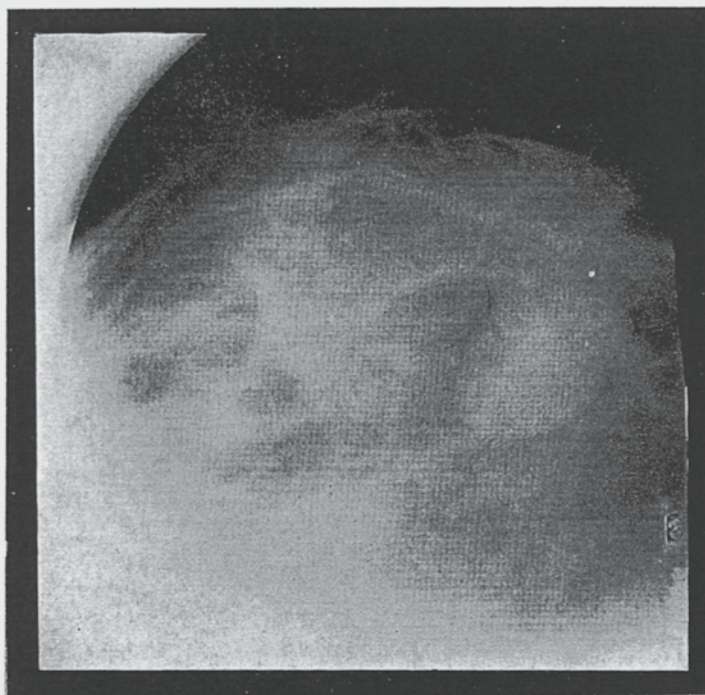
Même malade, radiographie dite de contact, tous les signes radiologiques sont plus accentués par rapport à l'image standard.
